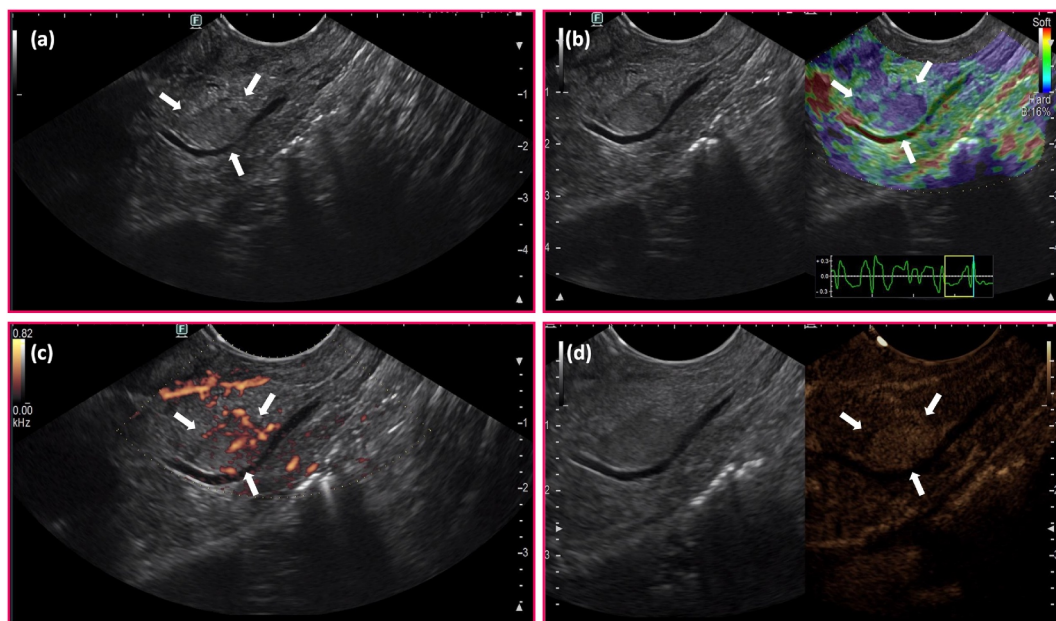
Endoscopic ultrasound (EUS) typical aspect of a pancreatic neuroendocrine neoplasm: (a) B-mode, (b) EUS-elastography, (c) Fine Doppler, and (d) EUS-contrast enhancement.
